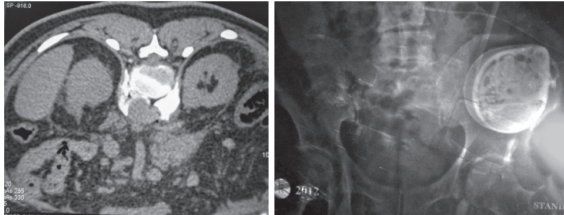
CT guided Coeliac Plexus block Fig. 12- Implantable Pump in situ
